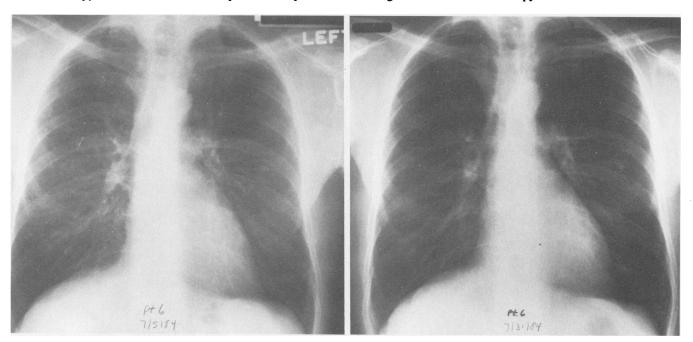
Chest roentgenograms in patient 6, before (left) DFMO therapy showing bilateral infiltrates and after (right) 24 days of treatment with DFMO as first-line therapy showing a normal study.
